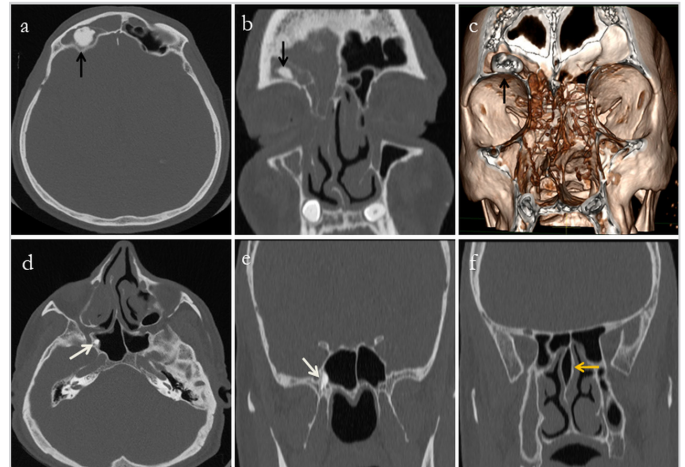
Osteoma in the right supraorbital ethmoid cell (black arrows) of a 49-year-old male patient. a, d) axial, b, e, f) coronal reformat, c) volume-rendering CT images. A second osteoma in the right sphenoid sinus (thin white arrows) and septum pneumatization (yellow arrow)
